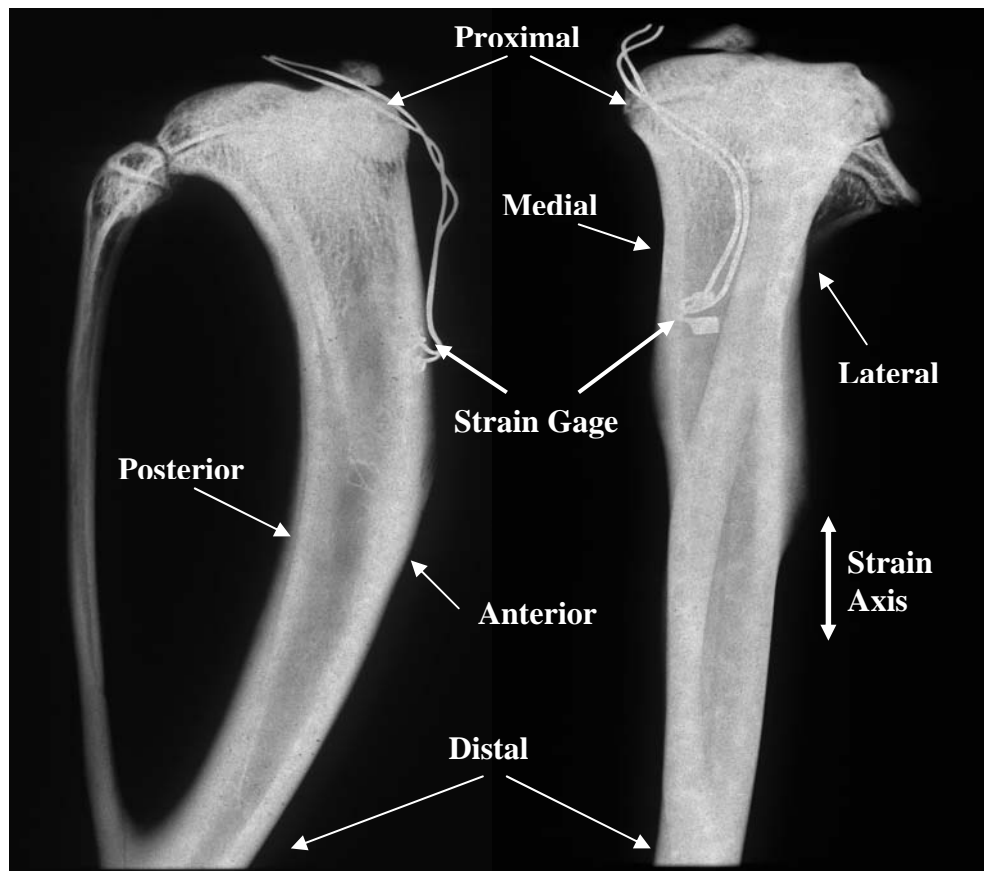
Contact radiographs of the sagittal and coronal aspects of a tibia with a strain gage attached.
